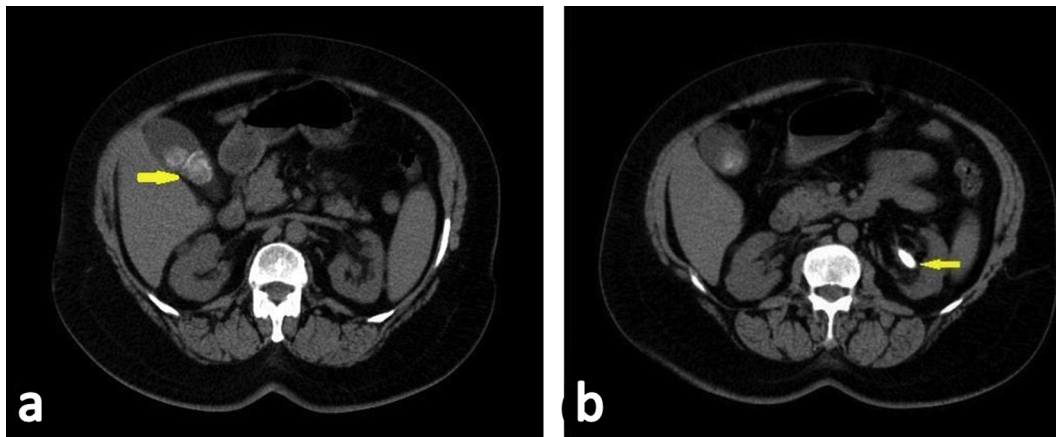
Fifty-two year old female patient with bilateral flank pain. CT stone protocol in axial plane at the level of gall bladder (a) showing gall bladder stones (arrow). (b) Axial scan at the level of left renal hilum shows a left renal pelvic stone (arrow).
